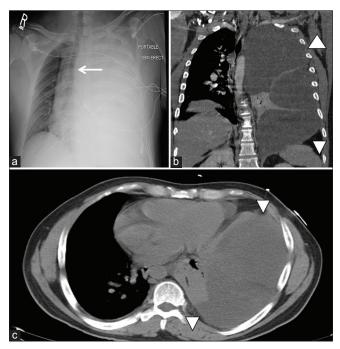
Pleomorphic intrathoracic liposarcoma in a 45-yearold male complaining of shortness of breath, chest pain, and cough. Chest plain film (a) showed a whiteout left hemithorax with mediastinal shift to the right (arrow). Coronal (b) and axial (c) computed tomography images of the chest demonstrated a large low-attenuation mass occupying most of the left hemithorax, associated with the complete collapse of the left lung (arrowhead). Note that the mass mimics a huge pleural effusion. Patient underwent left lung decortication and removal of multiple masses
